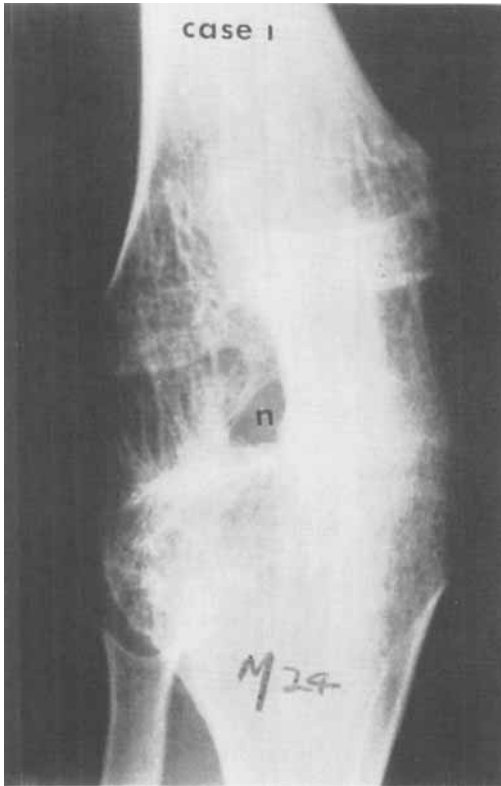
Case 1. Antero-posterior radiograph of right knee in 24-year-old male. Severe degloving injury of limb when aged 8 years. Note that bony fusion of the knee joint has occurred; inter-condylar notch still visible (n).
